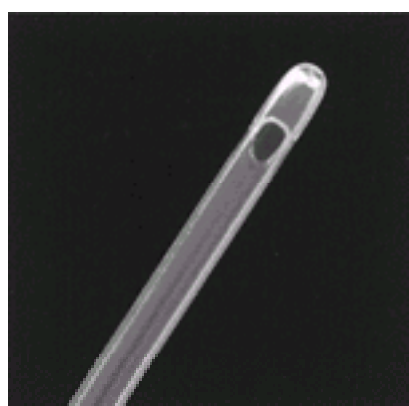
Saline infusion sonography catheter, insemination type.
